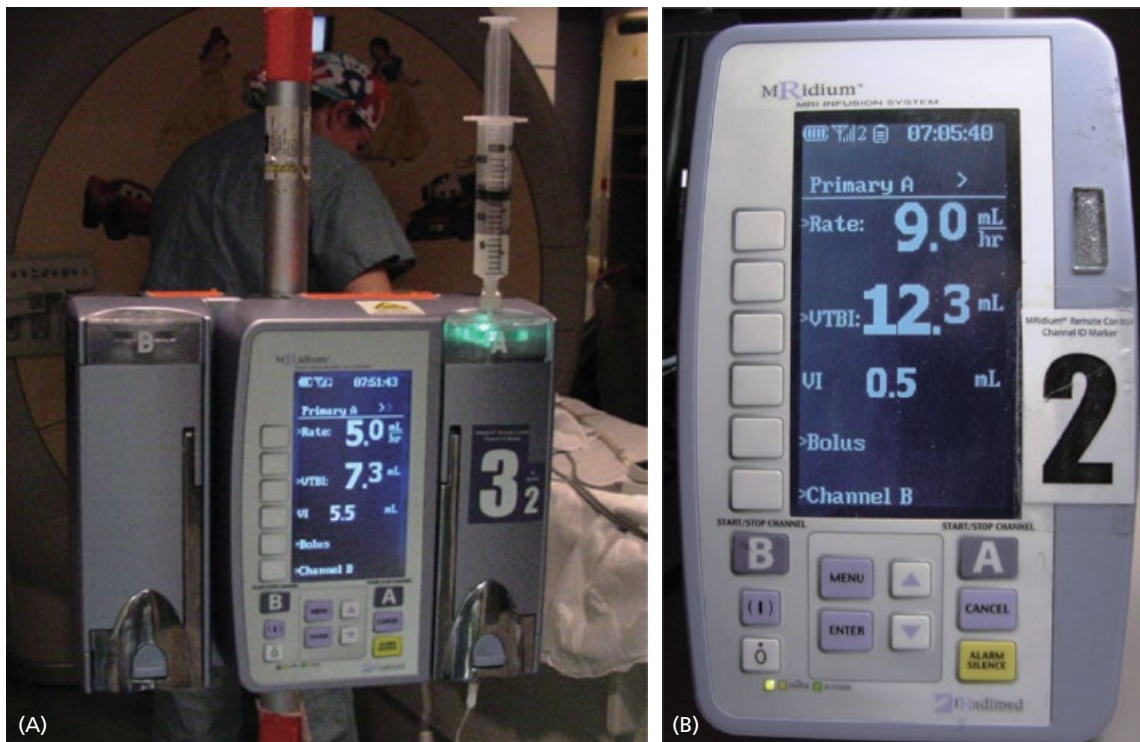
(A) MRI-compatible infusion pump in the scan room, with propofol infusing in a 7 kg infant. (B) Remote wireless display and controller.
